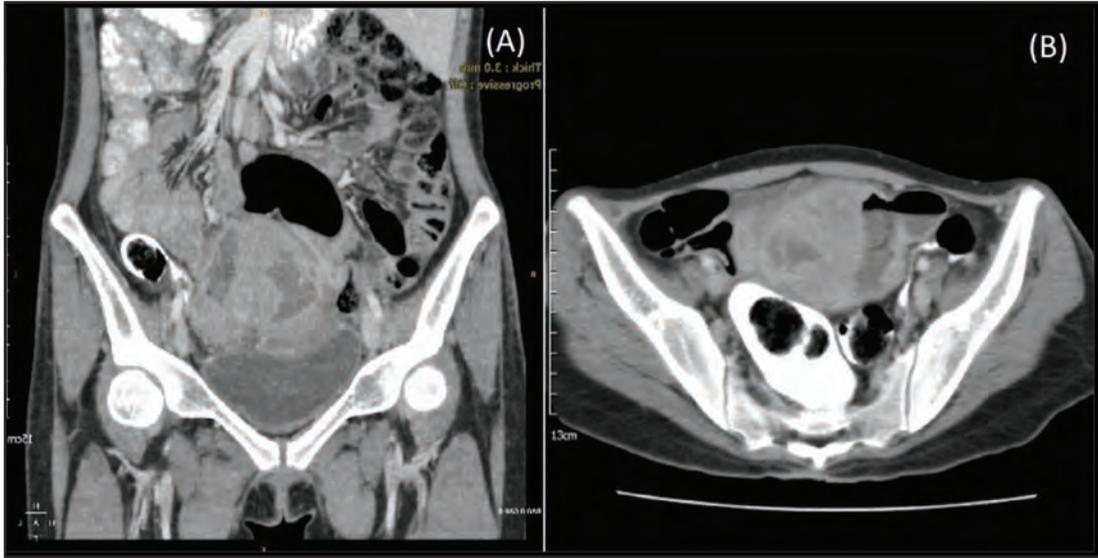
CT scan of the abdomen and pelvis (A: coronal view; B: axial view) showing a pelvic enhancing tumour (blue arrow) arising from the small bowel and adherent to the dome of the urinary bladder
